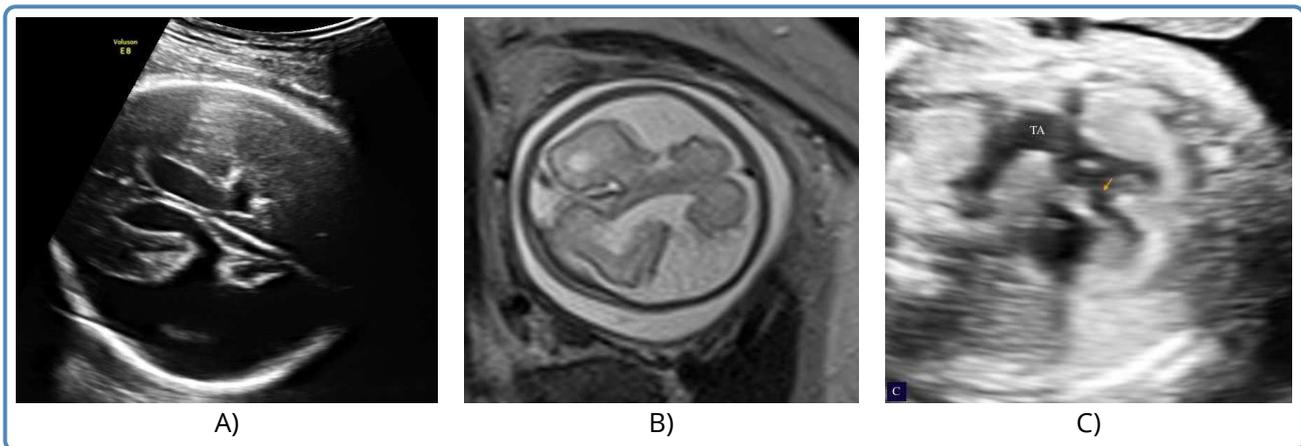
A) Fetal sonogram showing unilateral deep clefting of the Sylvian fissure in the left cerebral hemisphere extending up to the lateral ventricle. B) Fetal MRI showing the open type, large, unilateral schizencephaly. C) Fetal echocardiogram showing a common arterial trunk and ventricular septal defect (indicated with the yellow arrow).
